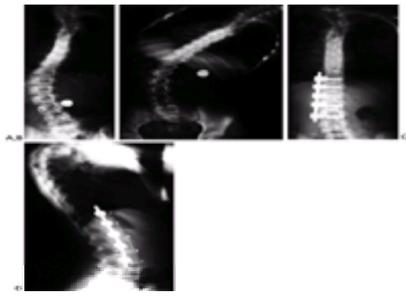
A: 12-year-old female who presented with a left lumbar scoliosis and trunk shift to the left. Of note, she also had a minor well-balanced congenital deformity of the upper thoracic spine. B: On side-bending to the right L3 leveled over the pelvis. Because this was the end vertebra of the curvature and it leveled on side-bending to the right, it was selected as the end-instrumented vertebra. C: The patient underwent anterior instrumentation and fusion with correction of the thoracolumbar curve. D: A lateral radiograph obtained 2 years postoperatively demonstrates solid arthrodesis and reasonable maintenance of lumbar lordosis.
